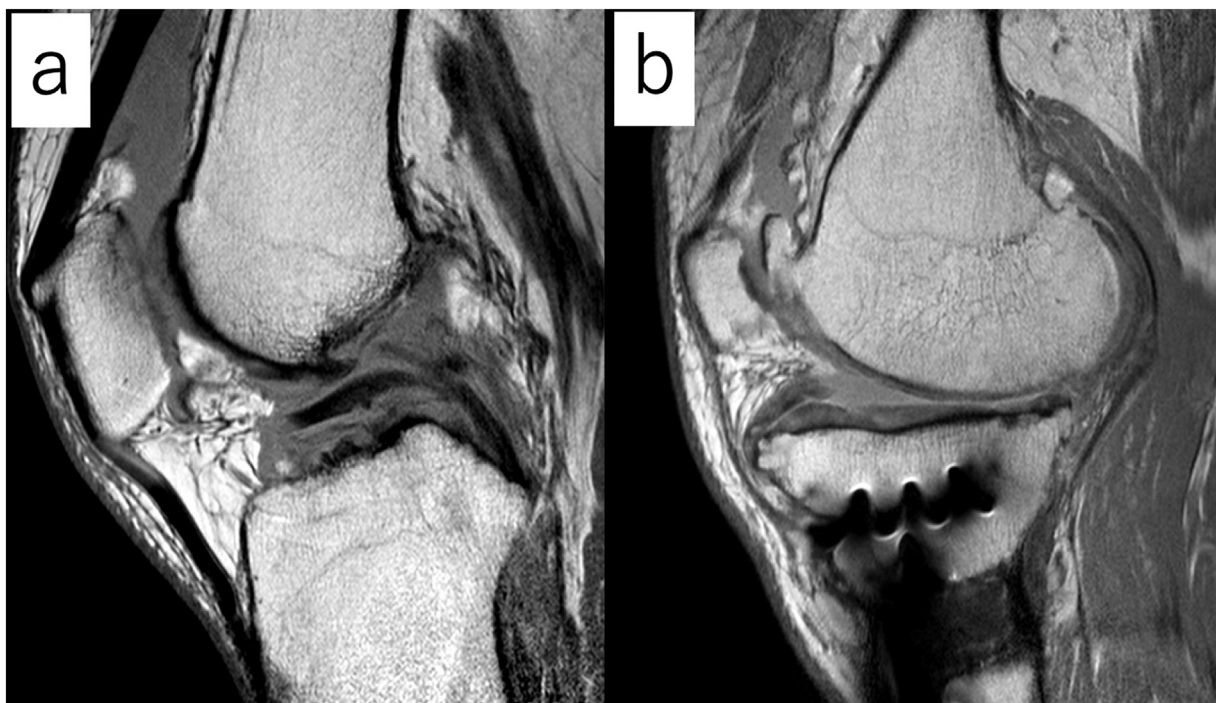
Magnetic resonance imaging T1 sagittal view showed anterior cruciate ligament was diminished before the first surgery (a) and anterior translation of tibia after the first surgery (b).
